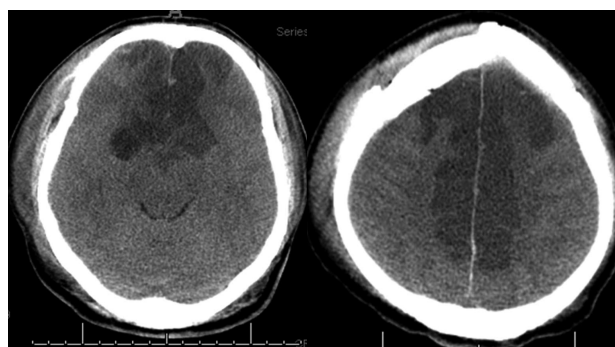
Follow up computed tomography scan showed extensive cerebral infarction in the territory of anterior cerebral artery.
